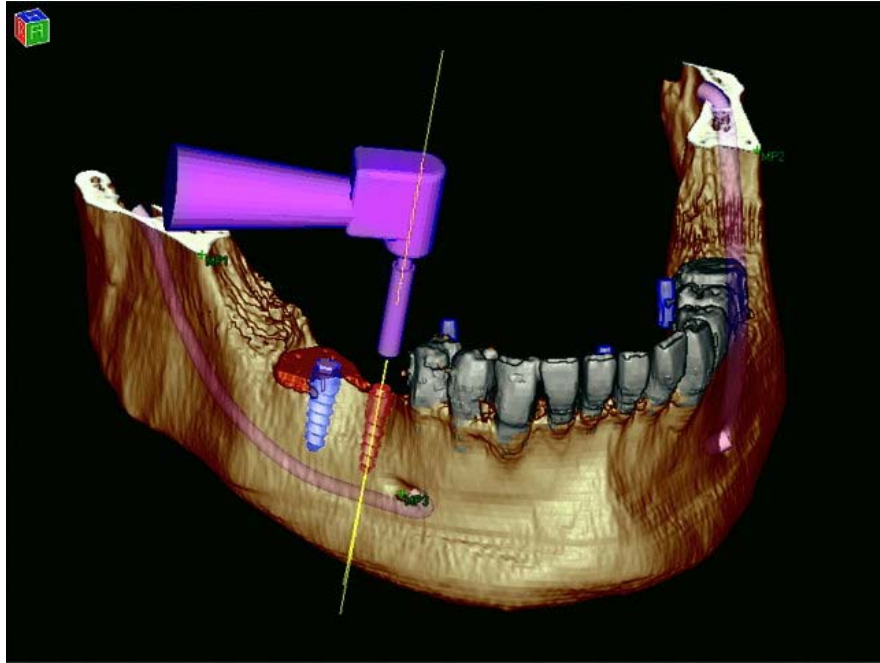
Surgical tool tracking. The position of the tracked surgical tool is recorded in real-time and projected onto the patients presurgical CT-data with the predefined surgical plan. Courtesy of IVS Solutions (VoNaviX CMF, IVS Solutions AG, Chemnitz, Germany).
